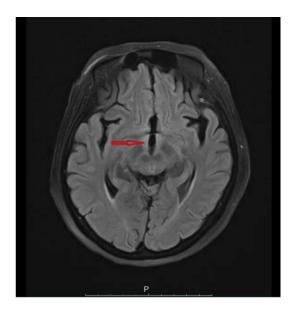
Typical case of thalamus and aqueduct lesion. T2-weighted and FLAIR sequences of brain MRI showed multiple lesions in the thalamus and aqueduct; Red arrows indicated hyperintense lesion area.
